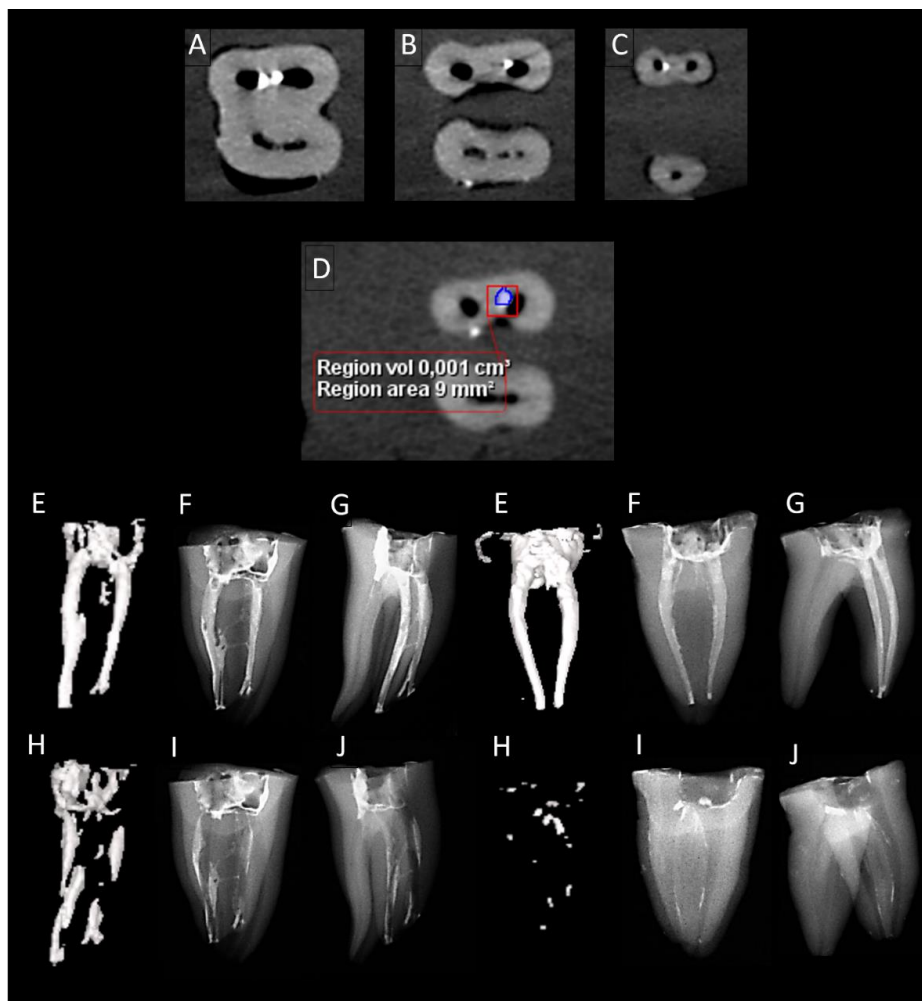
A) Residual filling materials in the cervical third from CBCT; B) Residual filling materials in the medial third from CBCT; C) Residual filling materials in the apical third from CBCT; D) CBCT Measure of the residual filling material volume; E) CBCT Reconstructions of the initial filling materials; F) Proximal X-ray views of the initial filling materials; G) X-ray in an angle view of the initial filling materials; H) CBCT Reconstructions of the remaining filling materials; I) Proximal X-ray views of the residual filling materials; J) X-rays in an angle view of the residual filling materials
